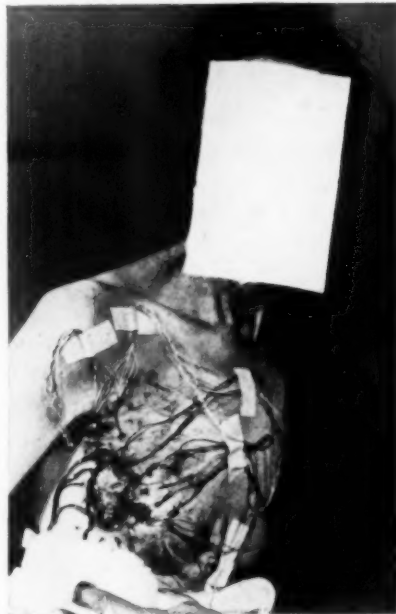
Inoperable carcinoma of the right breast. Thirty-two radium needles inserted into the breast and adjacent tissue for six hours. Surface application of radium and the x-ray, which preceded imbedding the radium, greatly reduced the mass in the breast.
